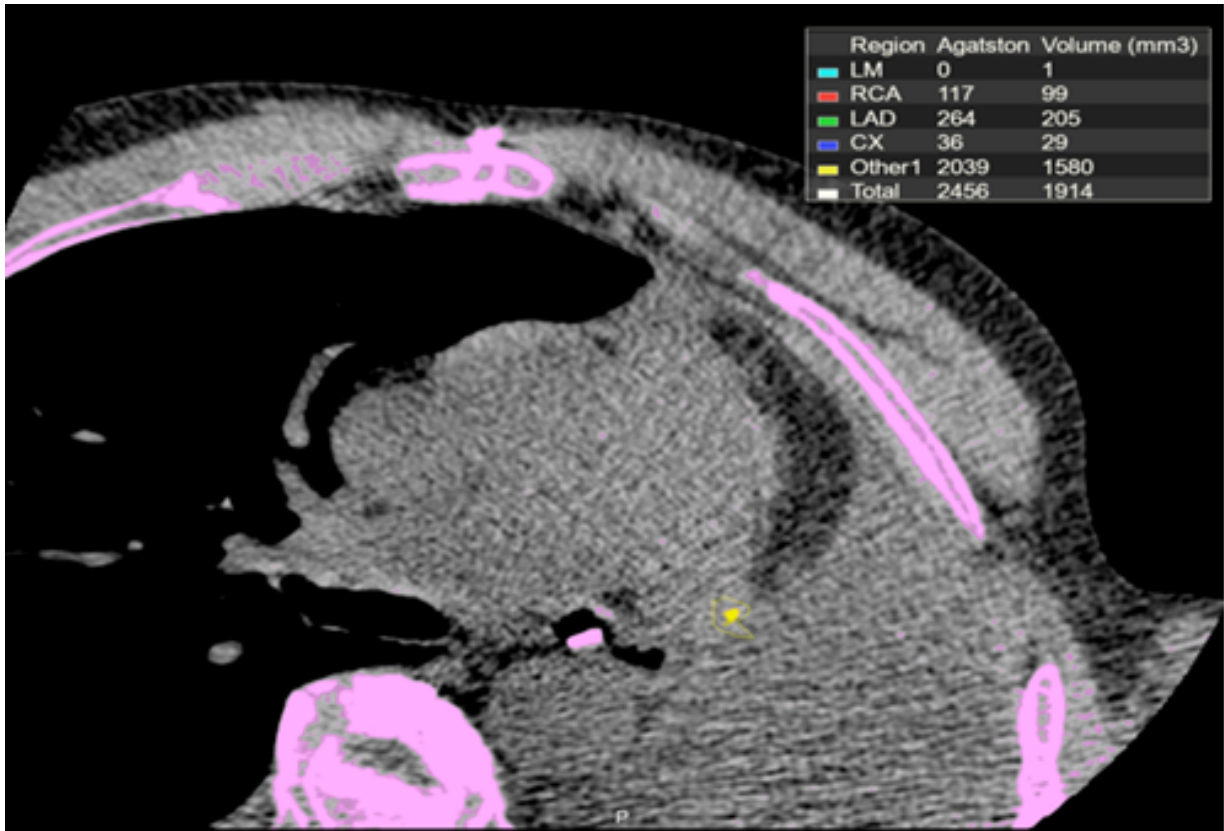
Example of coronary artery calcium scoring from a noncontrast CT. Agatston number is evaluated for each coronary artery. Final Agatston score, commonly referred to as the CAC score, is obtained by summing the scores for all the lesions in all coronary arteries.
